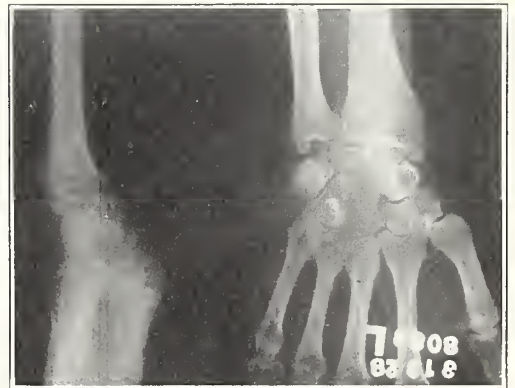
Roentgenogram showing dislocation of semilunar bone with beginning decalcification.
